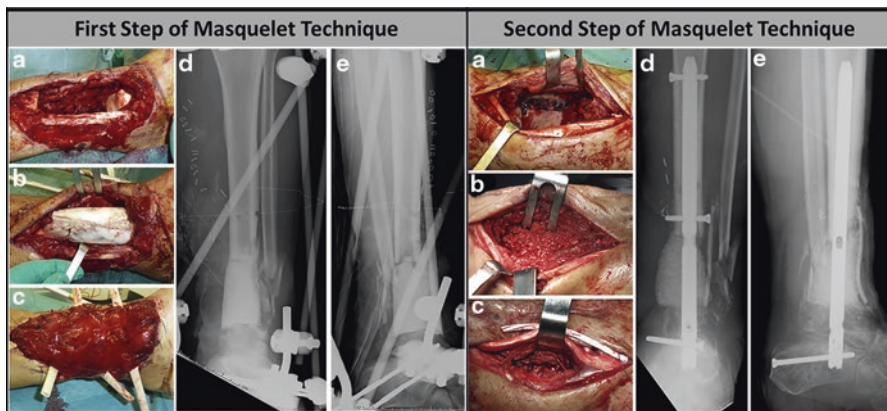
Scheme of a typical Masquelet technique in treating a tibial bone defect about 6 cm long. The first step included (a) bone debridement; (b) PMMA cement spacer bridging tibial and talus; and (c) Soft tissue coverage with gracilis free flap. (d) and (e) X-ray images of the cement spacer. The second step included (a) Opening of the defect and removal of the cement spacer; (b) Bone graft implantation in the cavity; (c) Closure of the membrane. (d) and (e) X-ray images graft and nail (Reprinted from [156], Copyright (2014), with permission from Elsevier)
